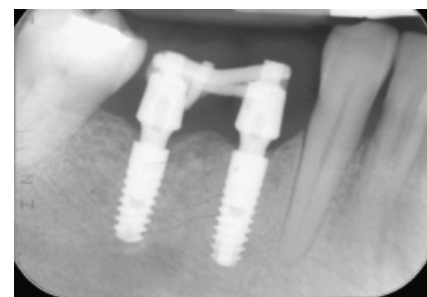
Test case: periapical radiograph taken 6 months after surgery.
